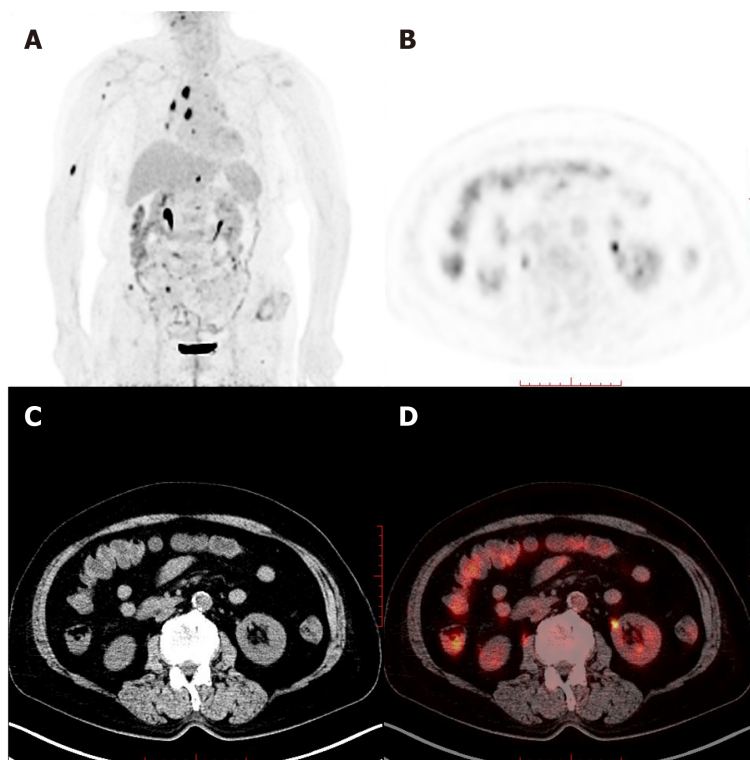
Whole-body maximum intensity projection 18F-fluorodeoxyglucose and positron emission tomography image. A: Remarkably increased fluorodeoxyglucose metabolism in the colon and mediastinal lymph nodes, as well as the right humerus; B: Positron emission tomography; C: Computed tomography; and D: Positron emission tomography/computed tomography in axial projection showed multiple tubular hypermetabolic lesions in the colon.
